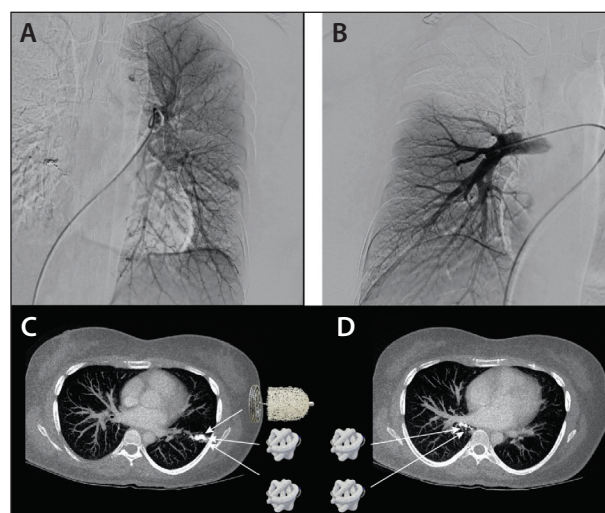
Preprocedural catheter angiography shows a single PAVM with two feeding arteries in the left lower lobe lateral segment (A) and a PAVM with one feeding artery in the right lower lobe posterior segment (B). Contrast-enhanced chest CT scan at 6-month follow-up shows a single PAVM treated with a 7-mm-diameter IMPEDE Embolization Plug and 4-mm X 10-cm TrelliX Embolic Coil in a 2.3-mm-diameter feeding artery and a 2-mm X 8-cm TrelliX Embolic Coil in a 1.7-mm-diameter feeding artery (C), as well as two TrelliX Embolic Coils (3 mm X 8 cm and 3 mm X 10 cm) placed in a single PAVM with a 1.6-mm-diameter feeding artery (D).
